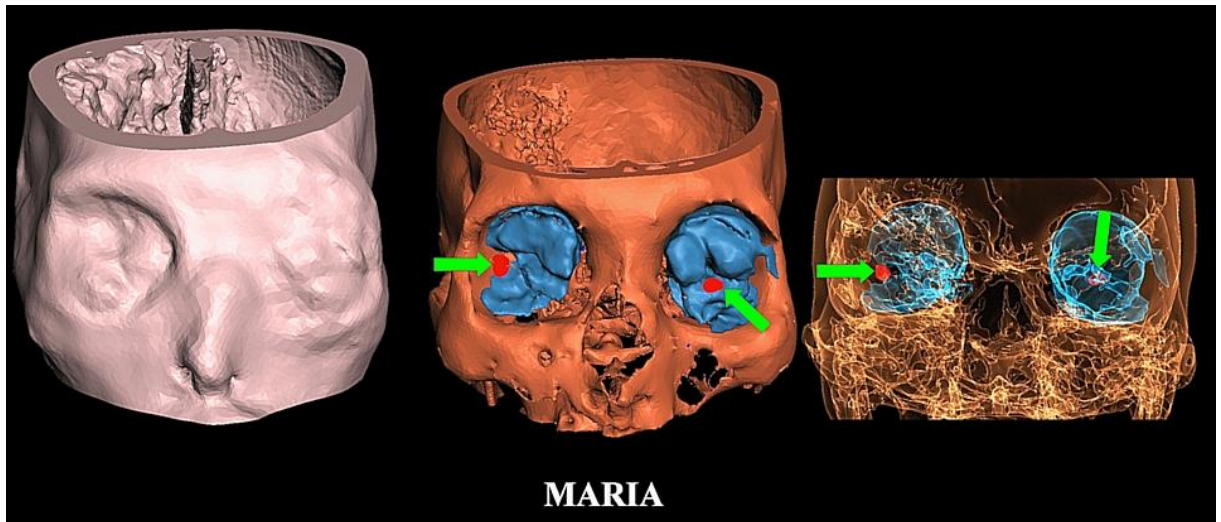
3D CT. Bone and ocular contents (*in blue*) are seen (*middle*) with semi-transparent view (*right*). *Green arrows* point to suspected lens structures (*in red*). Swellings were noted in left upper and lower eyelids and in adjacent left forehead as shown in surface view (*left*).
